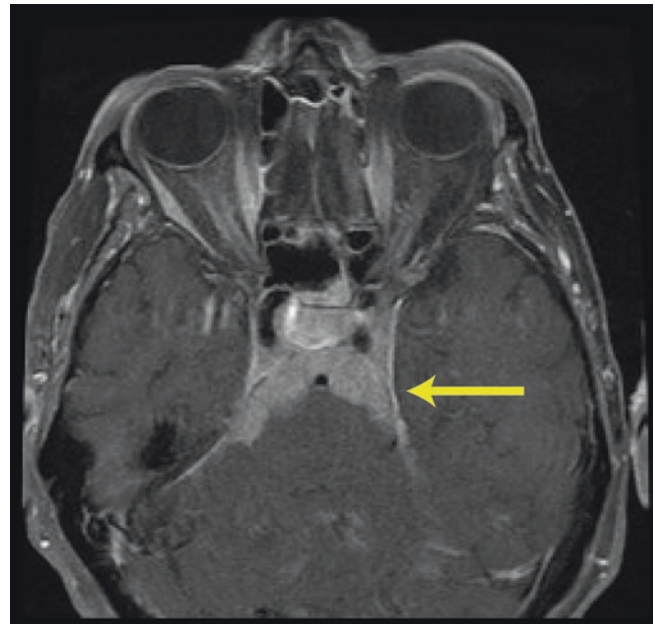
Contrast-enhanced magnetic resonance imaging (MRI) is the study of choice for demonstrating pachymeningeal thickening and enhancement. The dura may be smooth with homogeneous linear enhancement, or nodular with mass effect
